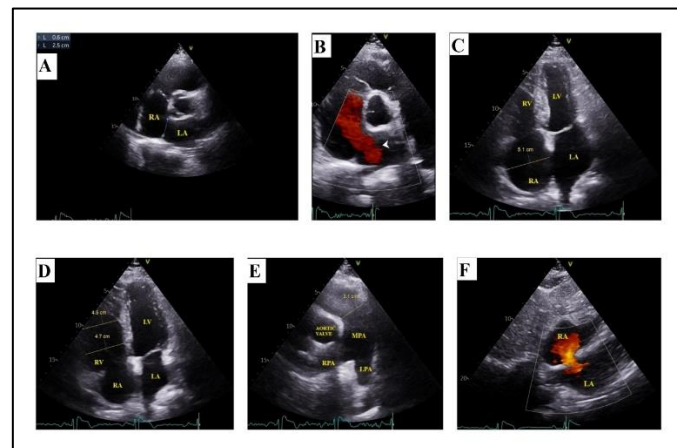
Transthoracic echocardiographic images (parasternal short axis view) showing 25 mm sized ostium secundum atrial septal defect with left to right flow (A,B), dilated right atrium, right ventricle and main pulmonary artery in apical 4-chamber and parasternal short axis views (C-E), subcostal view showing left to right shunt across atrial septal defect (F). LA- Left atrium, LV- Left ventricle, LPA- Left pulmonary artery, MPA- Main pulmonary artery, RA- Right atrium, RPA- Right pulmonary artery, RV- Right ventricle.
